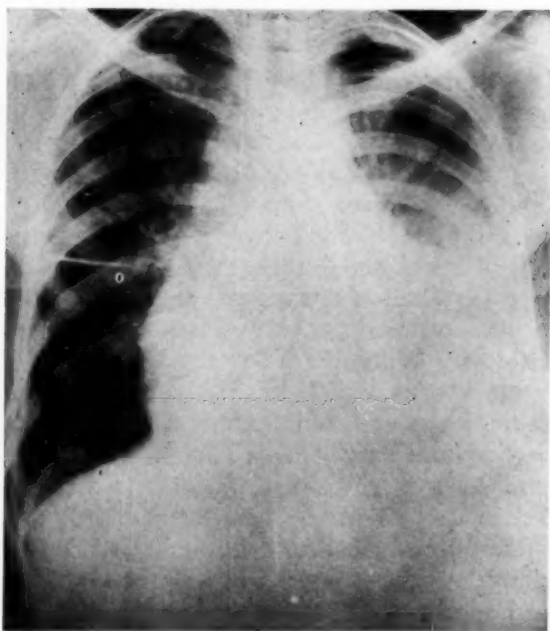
Posteroanterior roentgenogram of chest taken 3 months after admission.
